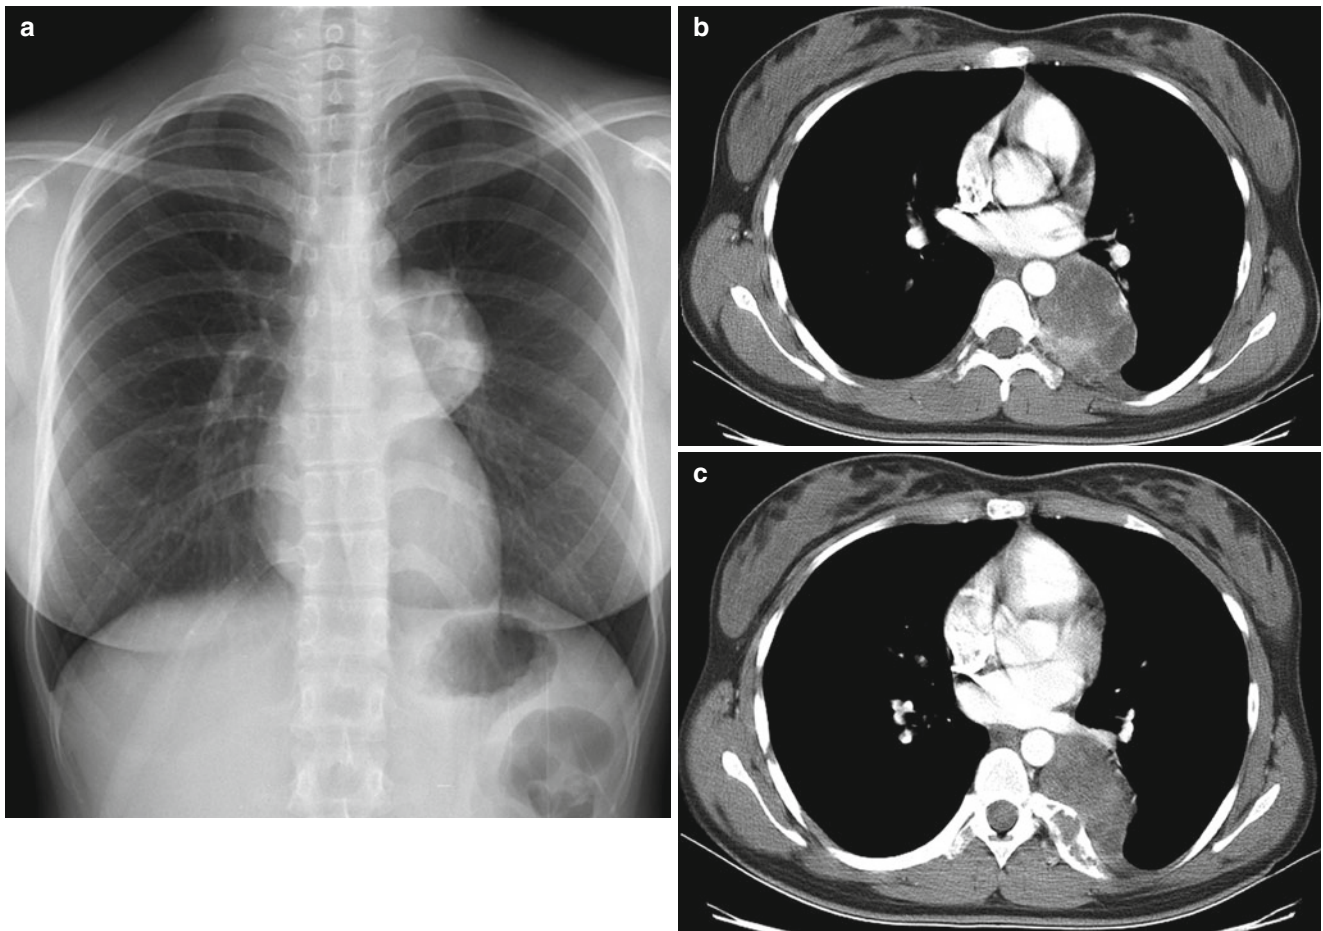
PNET (Askin) tumor in a 15-year-old boy (Case courtesy of Hye-Kyung Yoon, MD). (a) Plain radiograph shows an oblong left paraspinal mass. Note lytic changes and expansion of the posterior left
